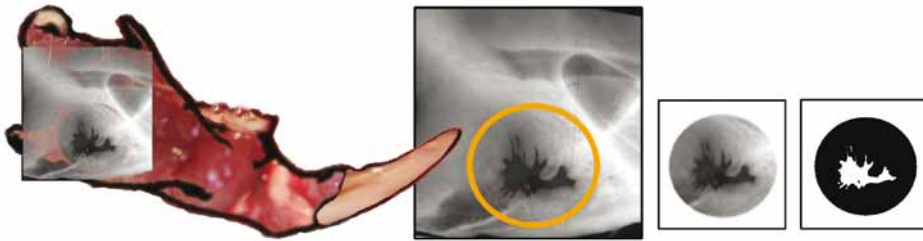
For micro-radiographic evaluation of the defects a 5.0 mm diameter circle was selected corresponding to the original defect. Based on the difference in grey values, the threshold of bone/no-bone boundary was determined for the selected area and applied. The remaining defect area was computed automatically and expressed as a percentage of the original defect size. [Image taken from ref. 21, used with permission]
